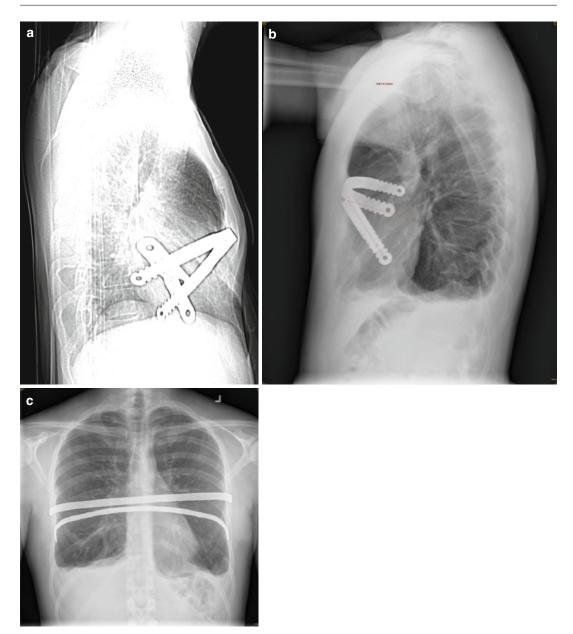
(a-c) Lateral chest and A/P roentgenograms show bar rotation and migration in three patients after Nuss pectus excavatum repair
